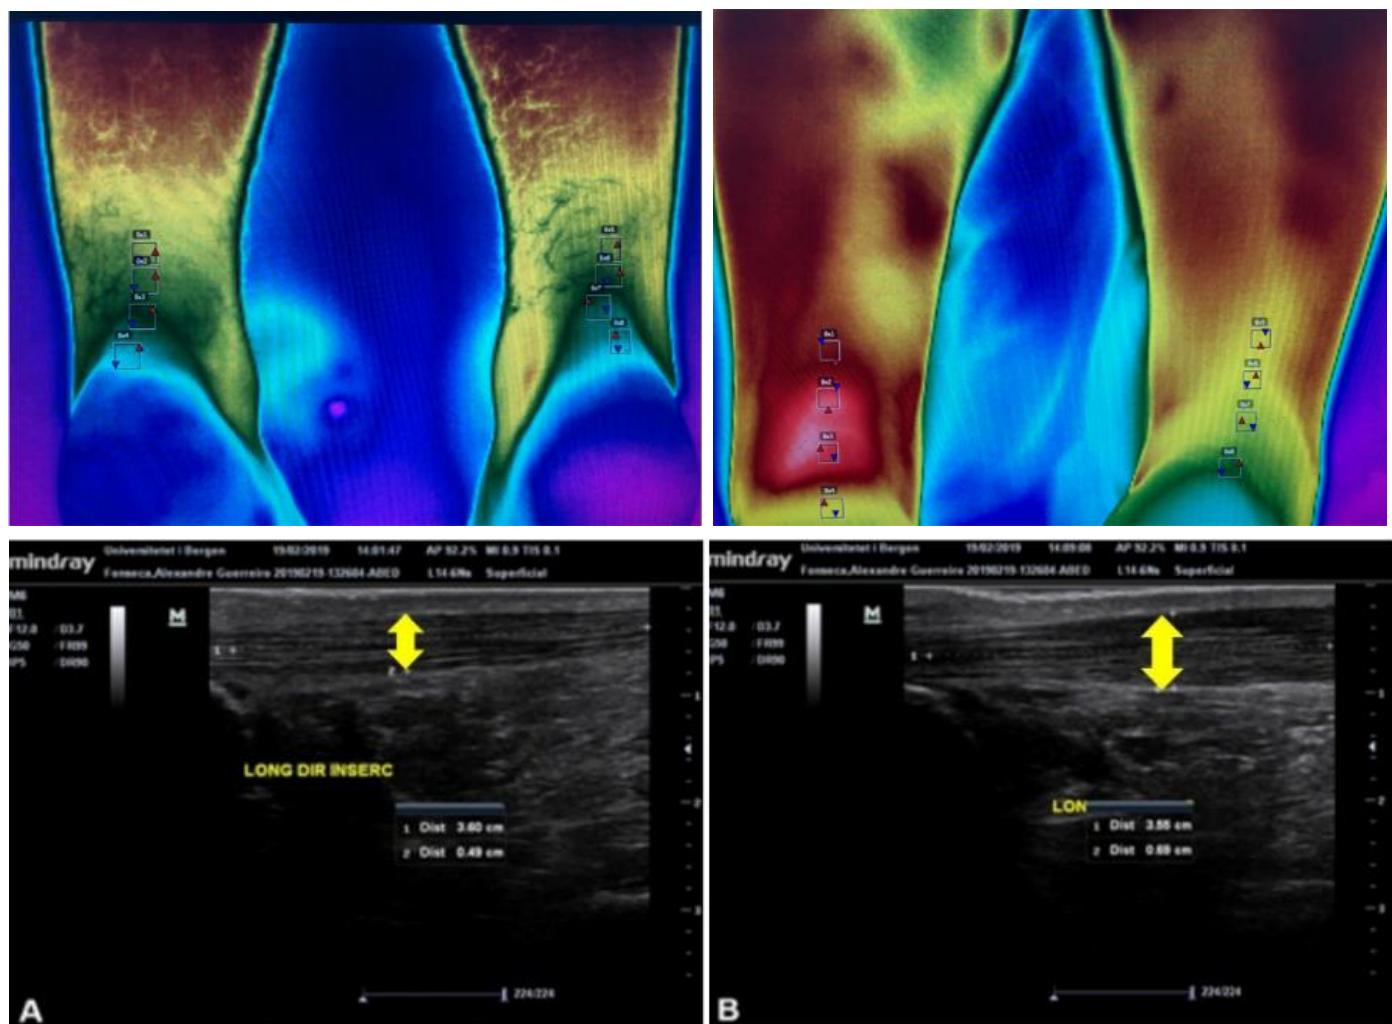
Representative image of Healthy tendons (left panel) and the affected (tendinopathy) tendons (right panel). The differences were confirmed by the image ultrasound showing the tendon thickening in the affected tendon (right image).
